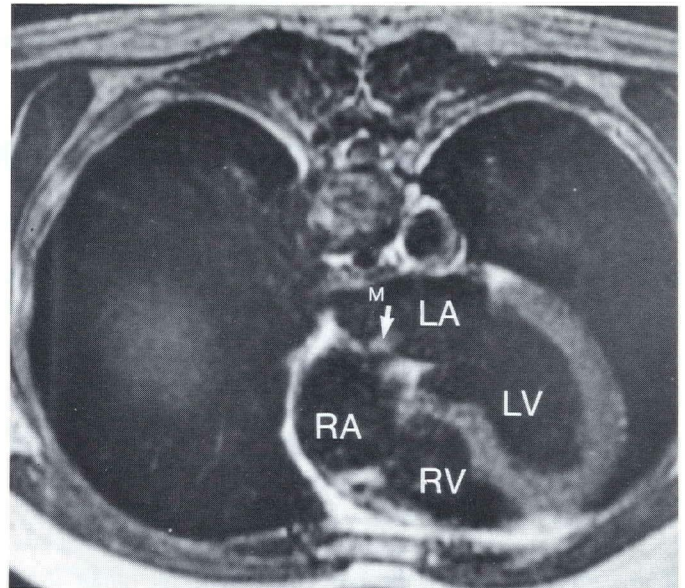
(Case 2)—Magnetic resonance imaging demonstrating the mass attached to the interatrial septum (arrow). (LA = left atrium, LV = left ventricle, RA = right atrium, RV = right ventricle.)
